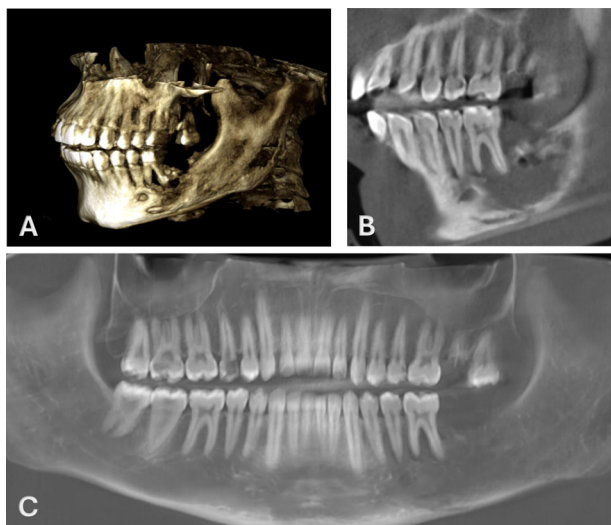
Cone Beam Computed Tomography (CBCT) post-extraction (38, 37) and minimal curettage of necrotic alveolar bone at 1 month post-operative. A) 3D reconstruction of mandibular defect B) Sagittal section showing radiolucent necrotic bone, loss of trabecular structure distal to tooth 36 C) Panoramic reconstruction showing healing in sector 3, extraction sites 15, 27, 28, 36. Endo (35), restorations (25, 46) were subsequently carried out.
